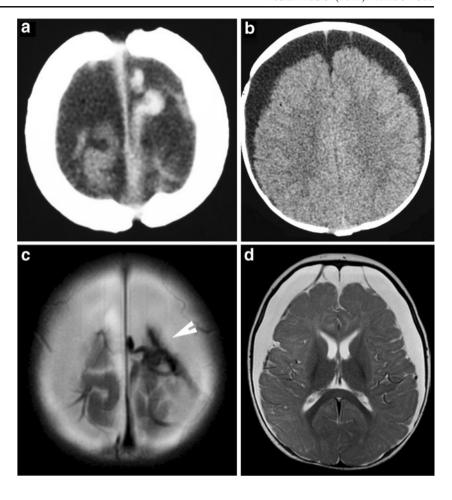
A case of confessed AHT in a 7-month-old boy presenting with recurrent vomiting. Chronic bilateral subdural haematoma (hypodense) with acute thrombosis of left bridging veins (arrowhead), i.e. hematoma of different ages. a, b Axial CT images. c, d T2-weighted axial MR images
